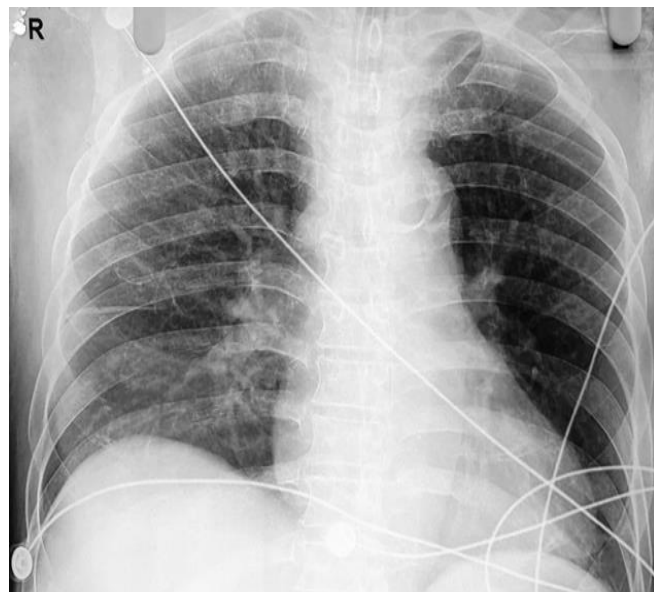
Chest radiograph showing resolution of left lung atelectasis post foreign body removal.
